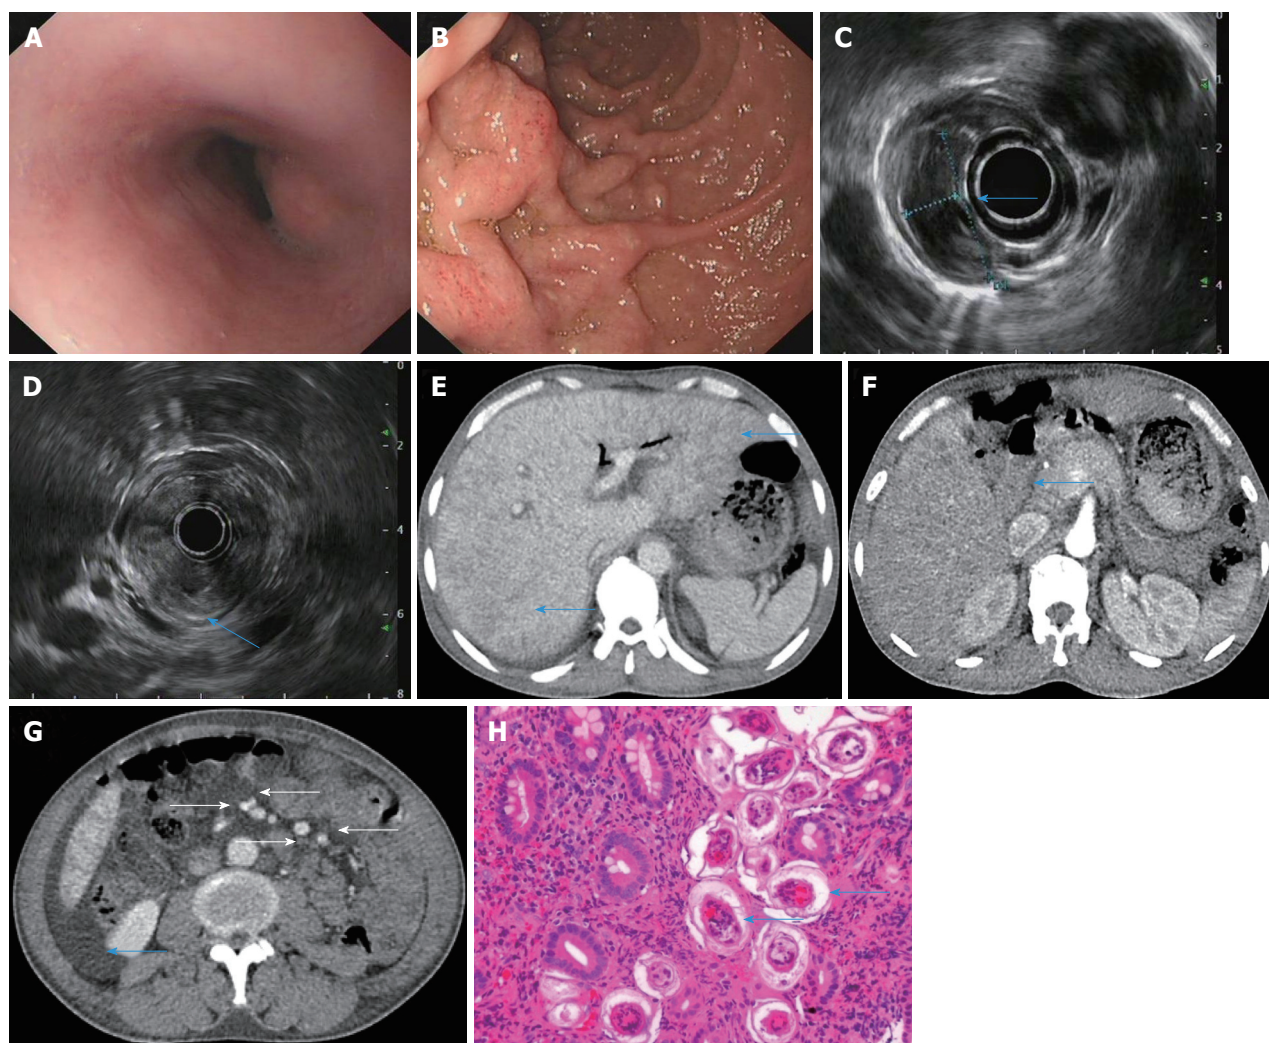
A 47-year-old male patient with acute *Schistosoma japonicum* infection underwent endoscopic examination, endoscopic ultrasonography and dynamic computed tomography scanning at the baseline visit. A, B: Upper gastrointestinal endoscopy showing protrusive lesions in the esophagus (A), swollen mucosa and protrusive lesions in the descending duodenum (B); C, D: Endoscopic ultrasonography revealing a hypoechoic mass in the muscularis mucosa of the esophagus (C, arrow), thickening of the descending duodenal wall, and destruction of the descending duodenal wall (D, arrow); E-G: Dynamic computed tomography showing heterogeneous hypointensity in the liver (E, arrow), thickening of the descending duodenal wall (F, arrow), swollen mesentery around the arteries (G, arrow), and ascites; H: Biopsy of the descending duodenum showing deposition of *Schistosoma* eggs.
